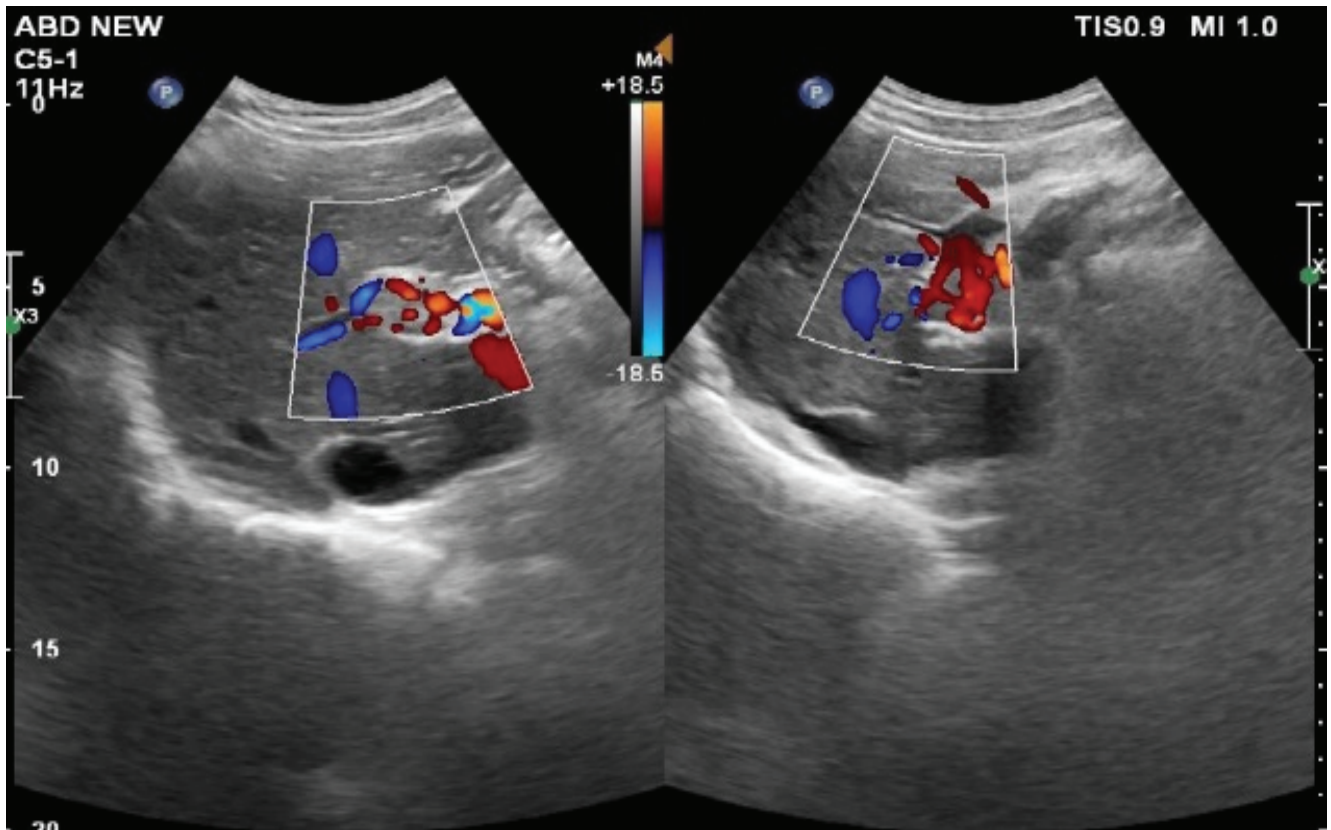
Doppler showing increased flow pattern in and around the portal vein thrombus
